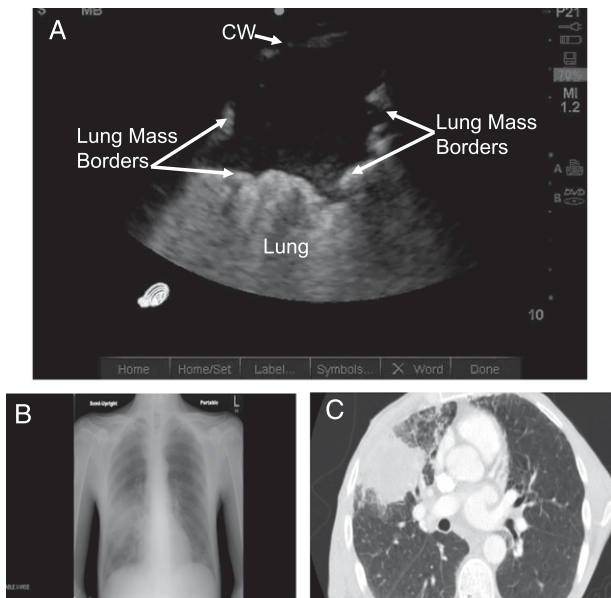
Lung mass. A, Ultrasonograph image of lung mass. Longitudinal scan, anterior right chest. Notice irregular borders with hypoechoic interior. B, Chest radiograph. C, Chest CT scan. Transthoracic biopsy proved non-small cell adenocarcinoma. See Figure 2 for expansion of abbreviation.
